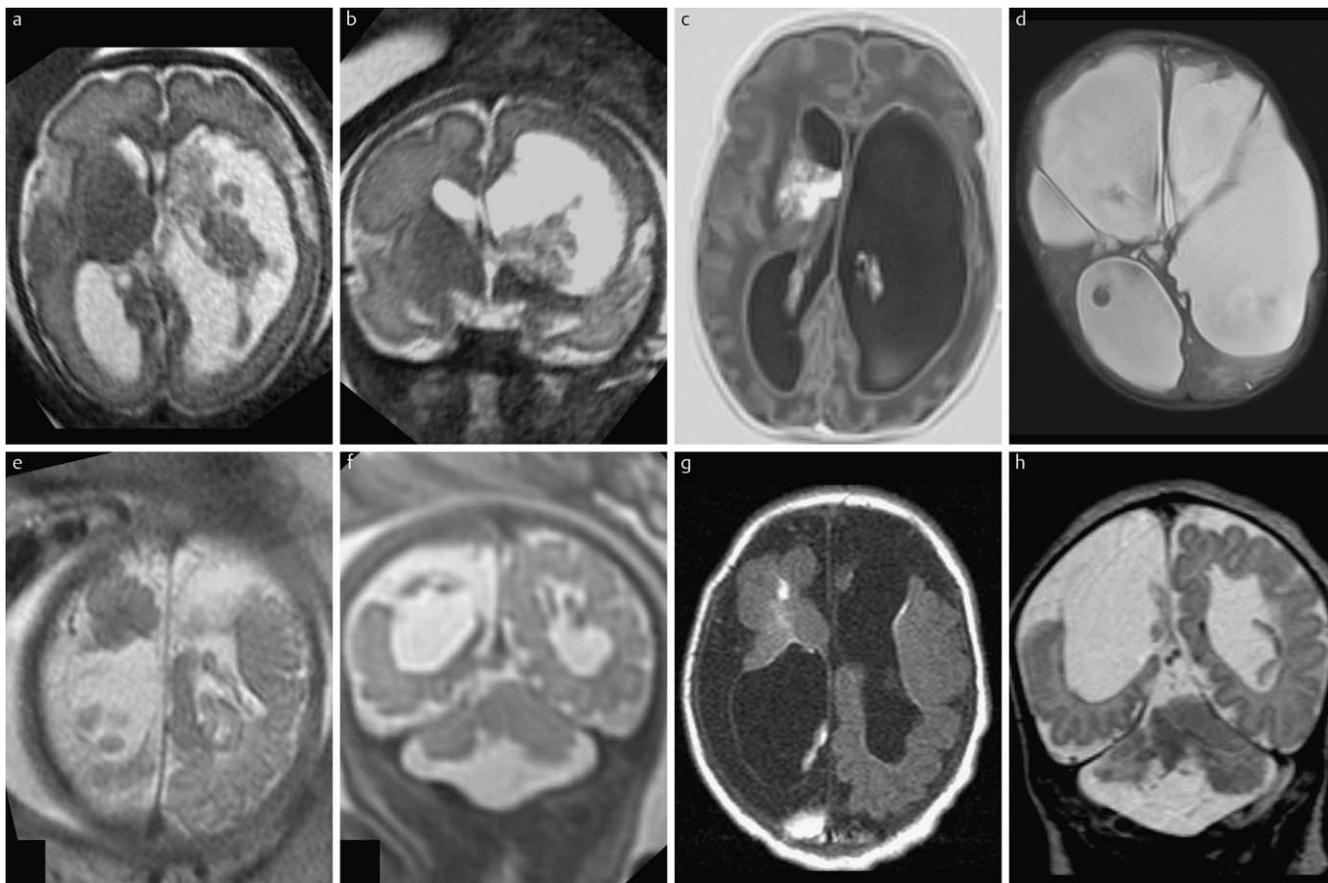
Patient A – Fetal single-shot T₂-weighted images at 35 weeks gestation; (a) transverse plane and (b) a coronal plane, showing the remains of a left intraventricular hemorrhage with widening of the left lateral ventricle and loss of the surrounding tissue (i. e., porencephaly). Postnatal MR images: (c) transverse Inversion recovery MR image (age 1 month) showing the pre-existent left intraventricular hemorrhage and a new hemorrhage in the basal nuclei on the right and (d) a single-shot T₂-weighted image at the age of 3 months showing severe bilateral hydrocephalus. Patient B – Fetal single-shot T₂-weighted images at 38 2/7 weeks gestation;
